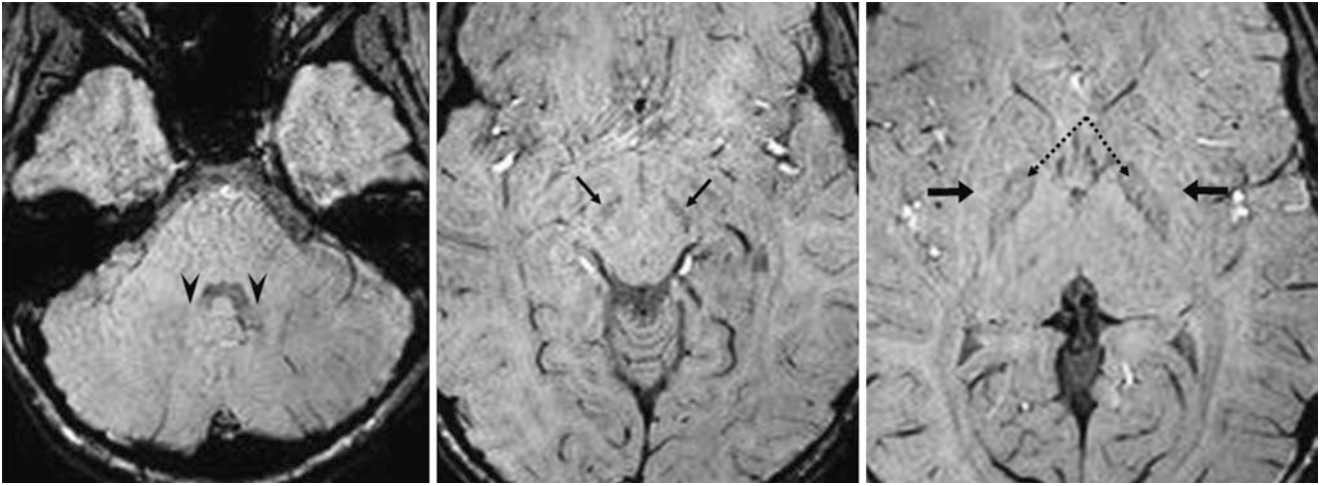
A 7 year old with growth deficits underwent a negative 3T MRI to evaluate the pituitary. Axial SWIs show no visible deposition of iron within the dentate nuclei (*arrowheads*), while there is early iron deposition within the SN (*thin arrows*) and GP (*dotted arrows*). *Arrows* indicate putamina
